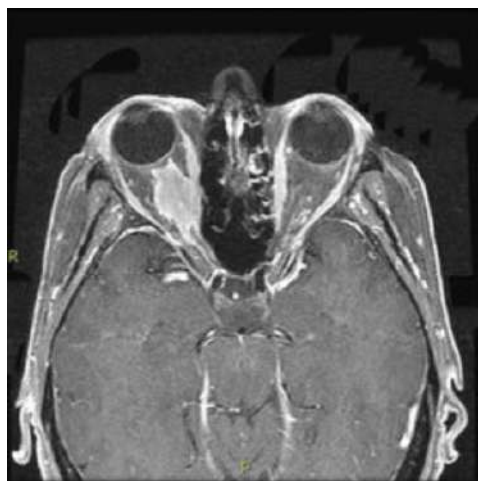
MRI imaging of Optic nerve sheath meningioma
